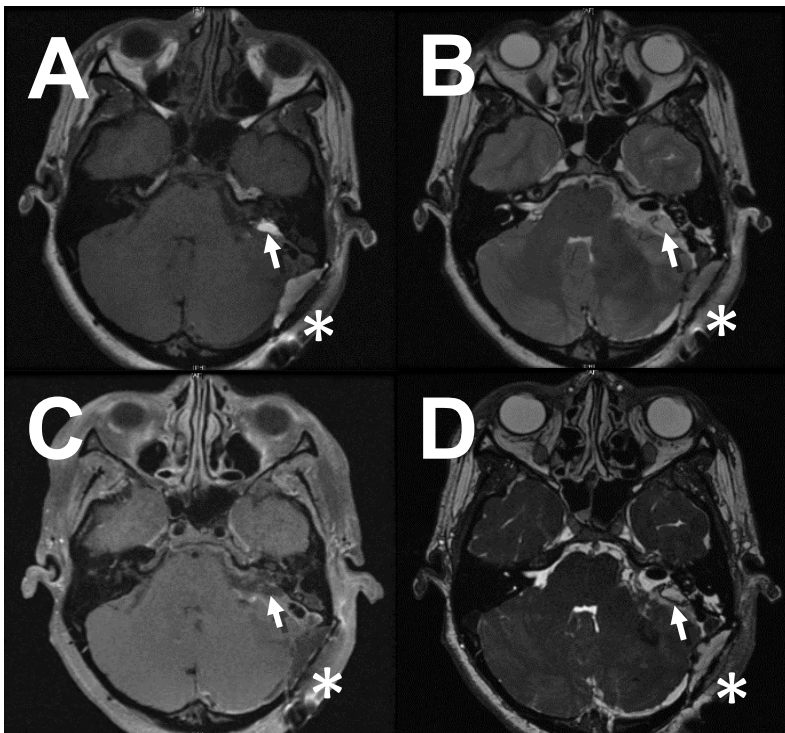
Immediate postoperative day 1 axial MRI after retrosigmoid transmeatal resection of left acoustic neuroma. Fat graft is placed in the internal auditory canal (IAC) defect (white arrow) and over retrosigmoid dural closure (asterisk). A: T1-weighted MRI, fat is hyperintense. B: T2-weighted MRI, fat is hyperintense with rim of hypointensity. C: Post-gadolinium fat-suppressed T1-weighted MRI, fat signal drops out and there is rim of hyperintensity from postoperative blood products. D: FIESTA MRI, fat is hyperintense with a rim of hypointensity.
